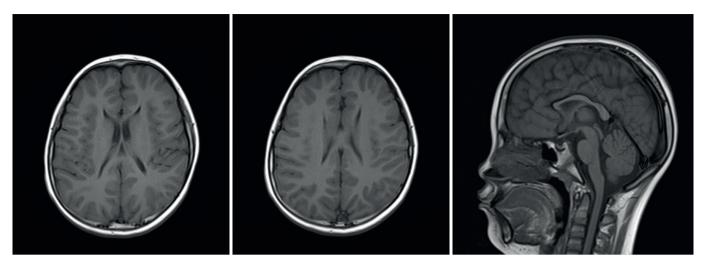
Axial and sagittal T1-weighted magnetic resonance imaging shows hypoplastic genu of the corpus callosum. No other abnormalities were noted.
